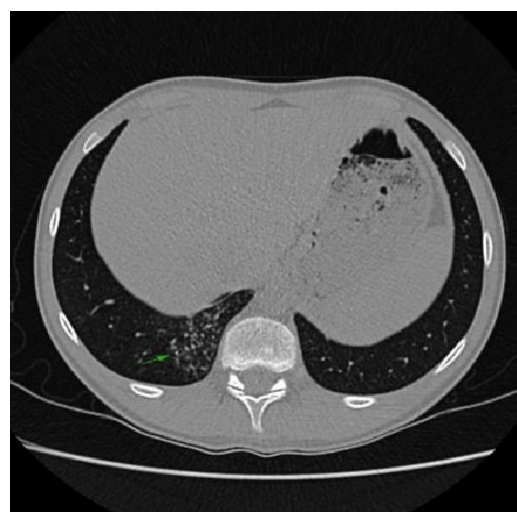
Left lower lobe bronchiectases and mucocele on CT scan (axial plane).
